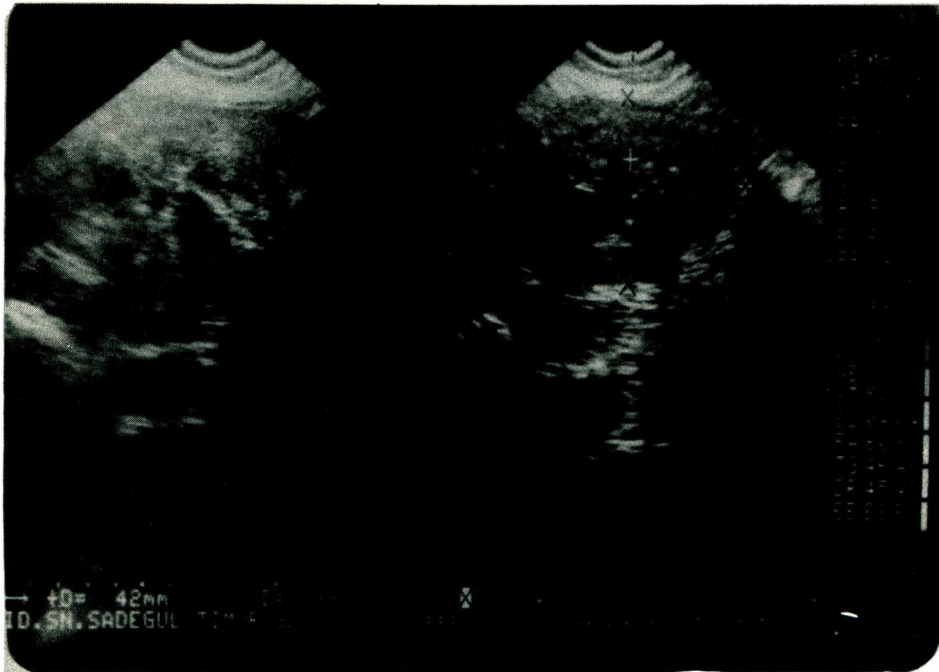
Ultrasonography showing the cystic and patchy necrotic areas in the liver.
